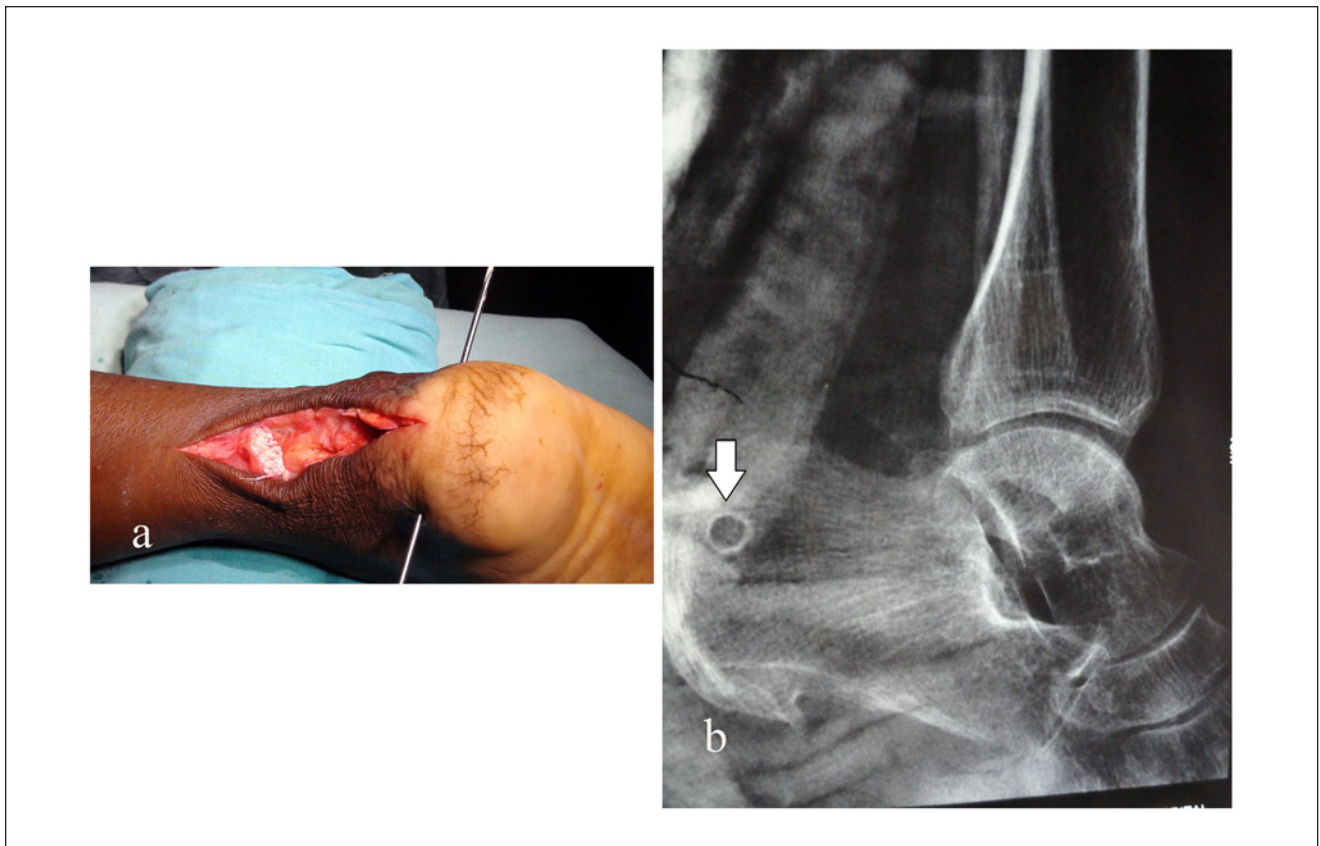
(a) A guide wire was passed from the medial to lateral side in the calcaneus, 1.5 cm below the point of insertion of the Achilles tendon. (b) A lateral radiograph showing a tunnel in the calcaneus (arrow) made by a 4.5-mm cannulated drill for passage of the prepared graft.
